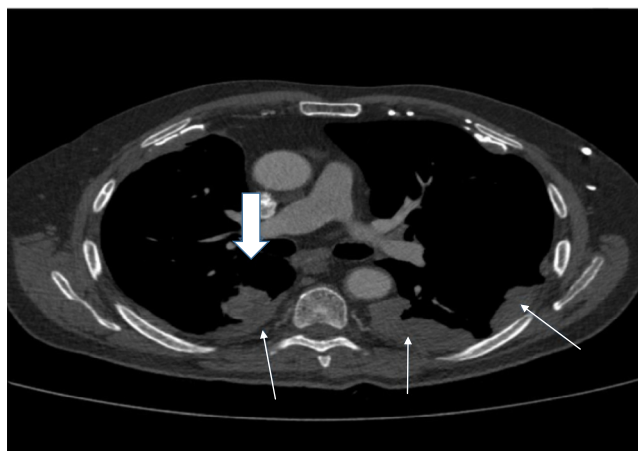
Computed tomography thorax showing new disease on the right chest lower zone affecting the medial and dorsal pleura over the medial and dorsal right lung lower lobe segments (white arrows and blue white arrow).
